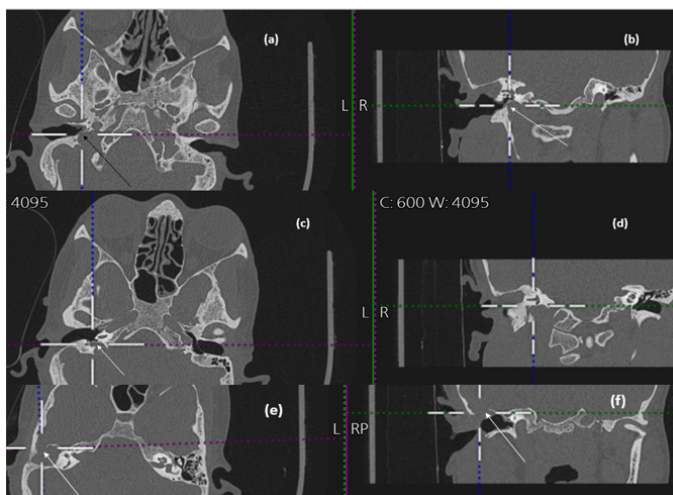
HRCT temporal bone showing
